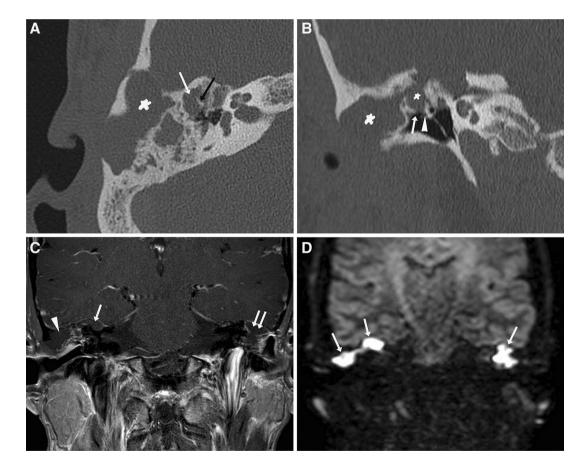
Acquired cholesteatoma. a Axial CT image of the right temporal bone shows lobulated opacity in the middle ear (white arrow) and mastoid (asterisk). The head of the malleus and the incus have been eroded, and only the manubrium of the malleus remains (black arrow). b Coronal CT image shows erosion of the scutum (arrow) and ossicles (arrowhead) by the cholesteatoma (asterisks). Note absence of pars flaccida (between the arrow and the arrowhead), which is
